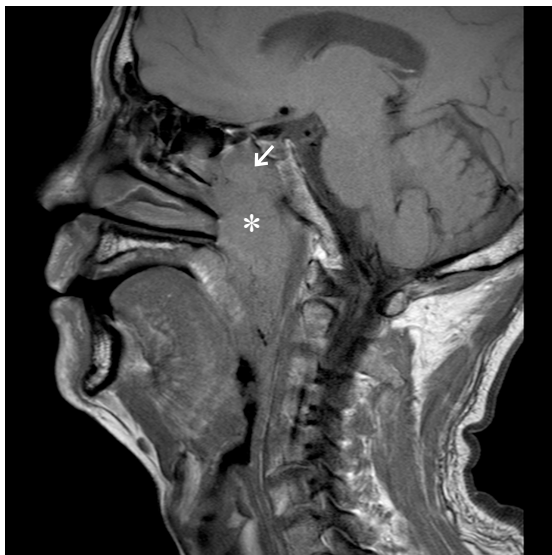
Sagittal T1W MRI shows large nasopharyngeal carcinoma (*) invading the sphenoid sinus (→).
